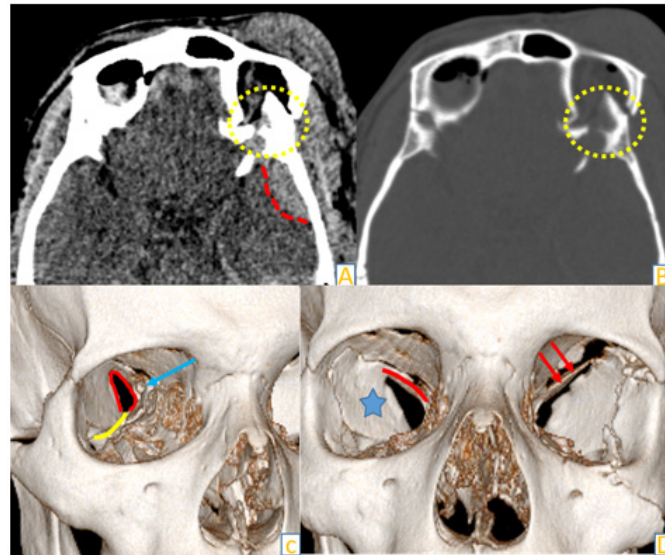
Axial Non-contrast CT scan brain soft tissue window (A) and bone window (B) show a large bony fragment of lesser wing of sphenoid bone within the superior orbital fissure (SOF) (yellow circle). Note is made of left anterior temporal region extradural hemorrhage (red broken line). 3D volume rendered image normal right orbit (C) demonstrating the normal anatomy of SOF which is continuous with inferior orbital fissure (red and yellow lines). Note is made of right optic nerve foramen (blue arrow). 3D volume rendered image of both orbits (D) demonstrating greater (blue star) and lesser wing of sphenoid (red line) in right orbit. Left orbit shows a large bony fragment occupying the left SOF (red arrows).
